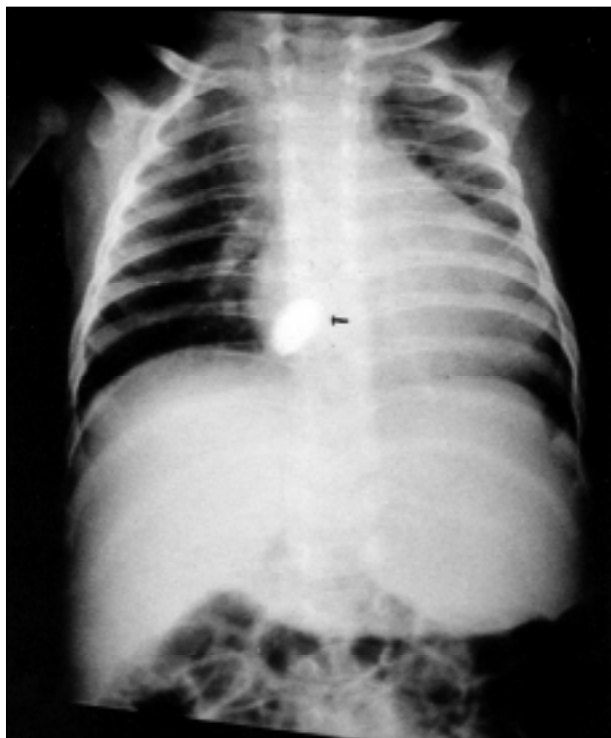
Chest X-ray (posteroanterior view) performed after the procedure showing the location of the inflated balloon (arrow) in relation to the cardiac chambers.
